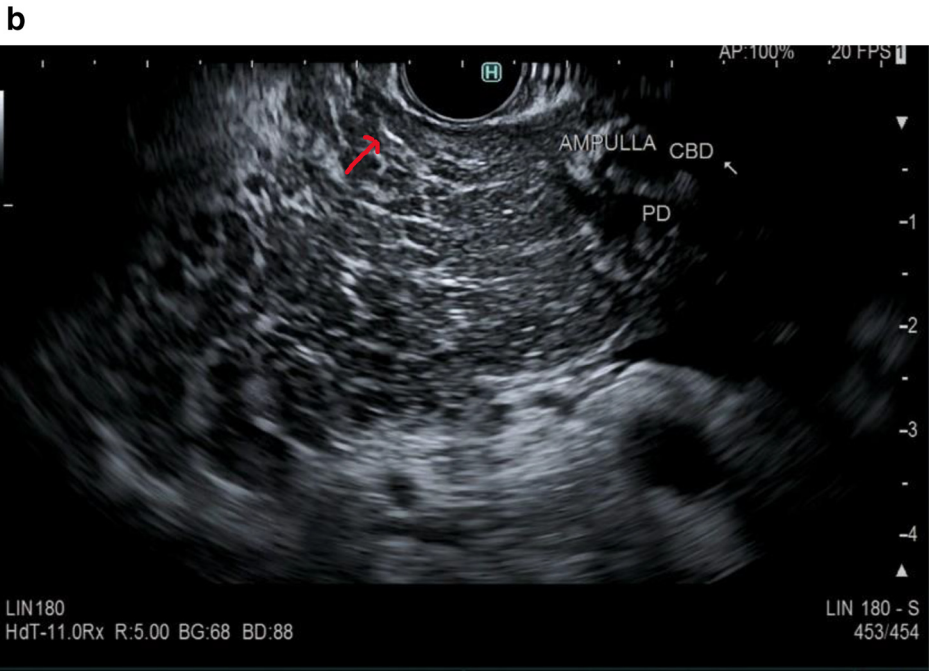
Endoscopic Ultrasound (EUS) showing dilated pancreatic duct
